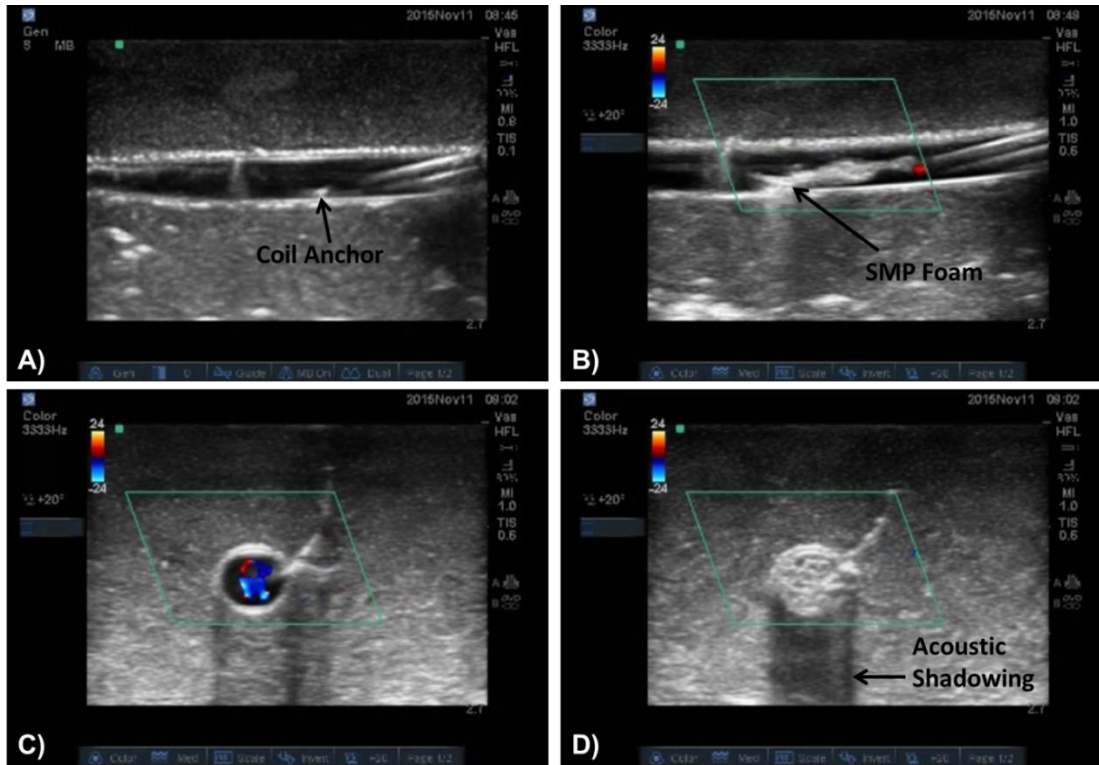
Doppler ultrasound images showing the catheter tip and coil anchor deployment (A), foam expansion and the parallel hyperechoic lines indicating the placement of the delivery sheath (B), a cross-sectional view of the mock vessel with flow (C), and a cross-sectional view of the vessel showing flow stagnation and significant acoustic shadowing after foam expansion (D).
